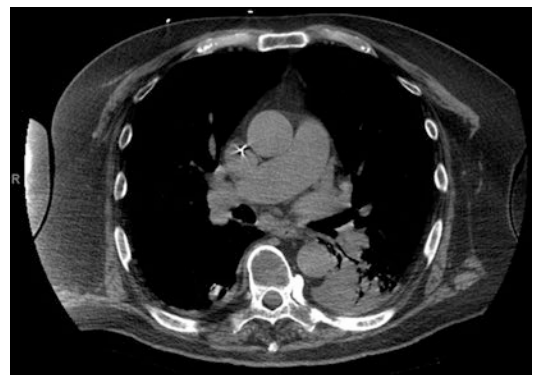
CT scan demonstrating pneumonia in the left lower lobe a Pulmonary to Aorta ratio greater than 1
